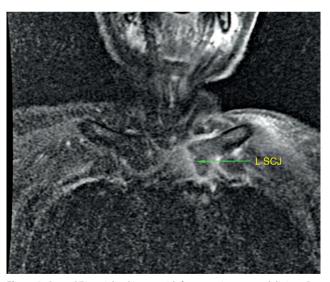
Coronal T1-weighted image with fat saturation post gadolinium: Destruction of the left sternoclavicular joint and diffuse contrast enhancement is shown, due to septic involvement (green arrow).
